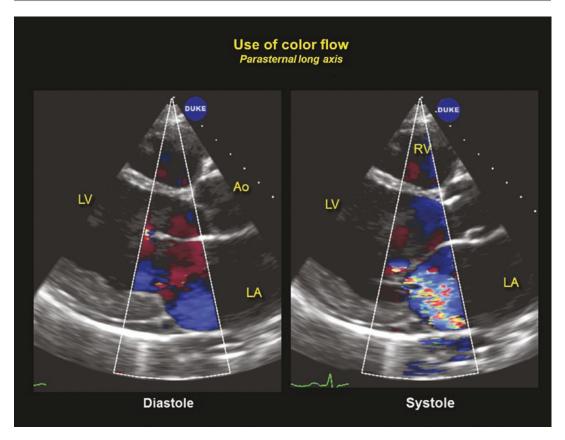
Diastolic and systolic still frames from a parasternal long axis of the left ventricle in mild mitral regurgitation
